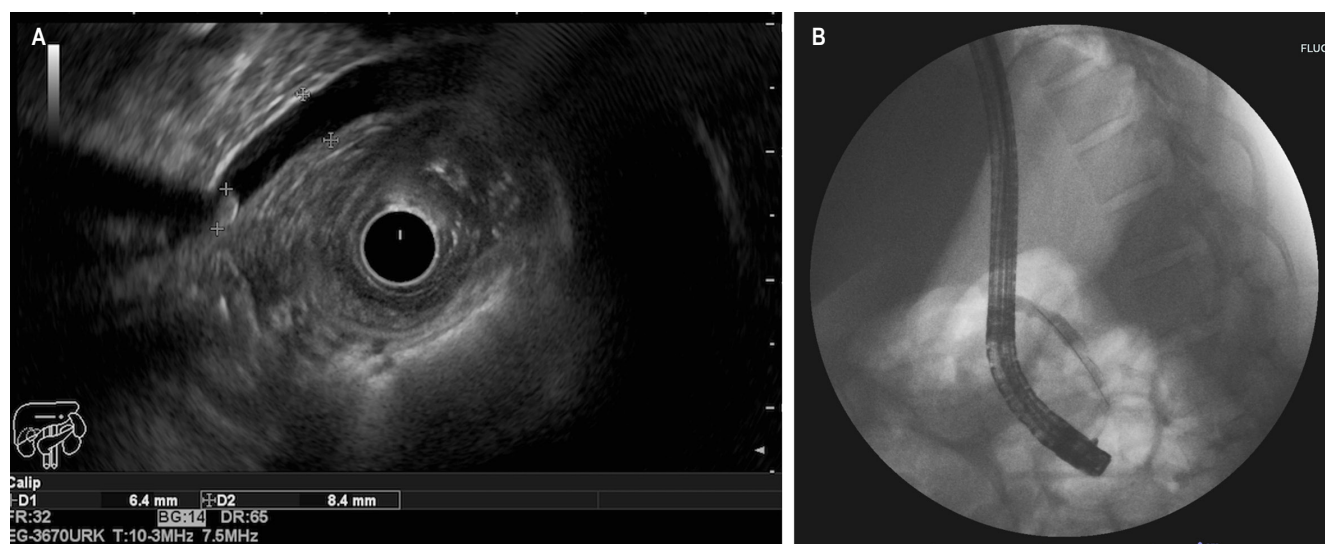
Diagnostic Imaging. A. Endoscopic ultrasound of the biliopancreatic region showing distal common bile duct dilation to 8.4 mm with a 6.4 mm biliary stone in its distal third. B. Fluoroscopic image from ERCP showing a 6 mm CBD and a 5 mm stone, successfully extracted without complications. Author's File.
